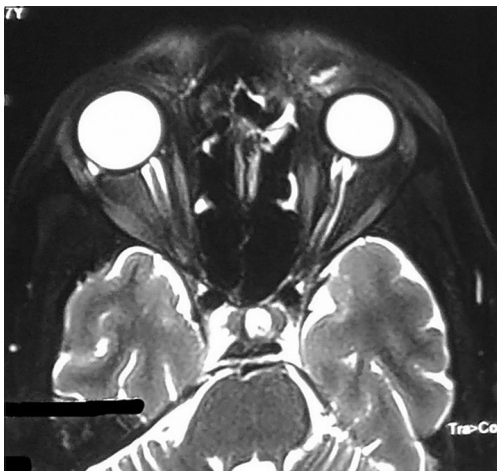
MRI with temporal and cavernous sinus region
